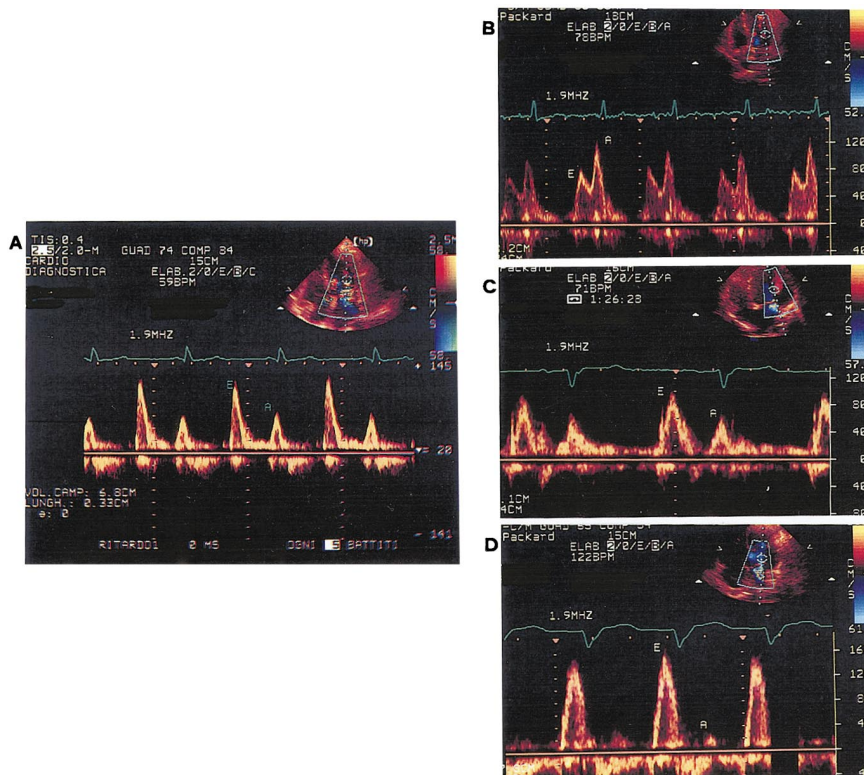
Mitral Doppler flow profiles and E/A ratios of the normal young subject (A), delayed relaxation (B), pseudonormal filling (C), and restriction (D).
